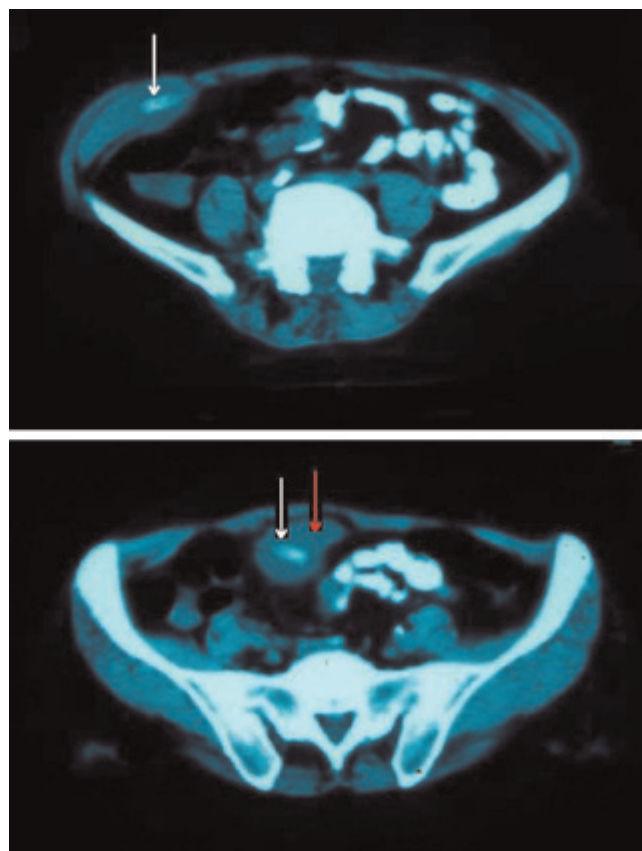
CT showing the localisation of the drain that migrated in the right iliac fossa. White arrow indicates the drain, while red arro indicates the abscess.
